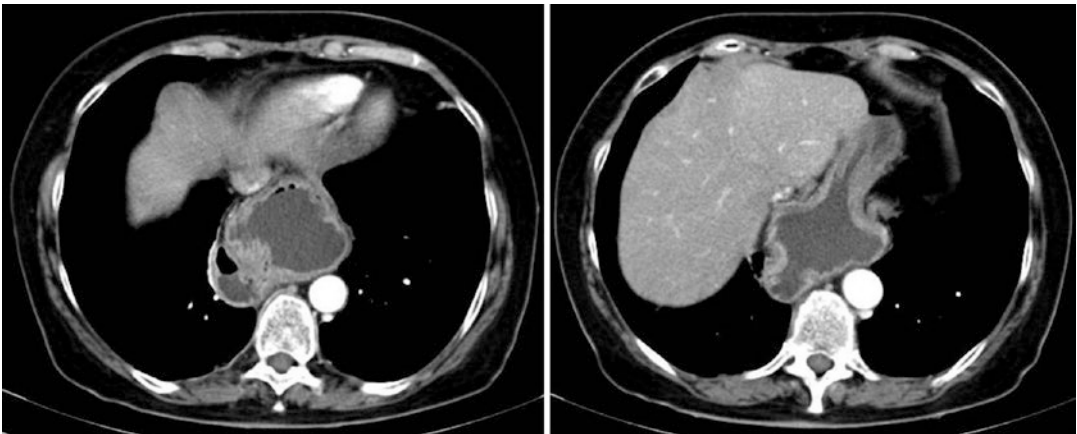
Computed tomographic scan in a patient with chest herniation of a Nissen fundoplication
